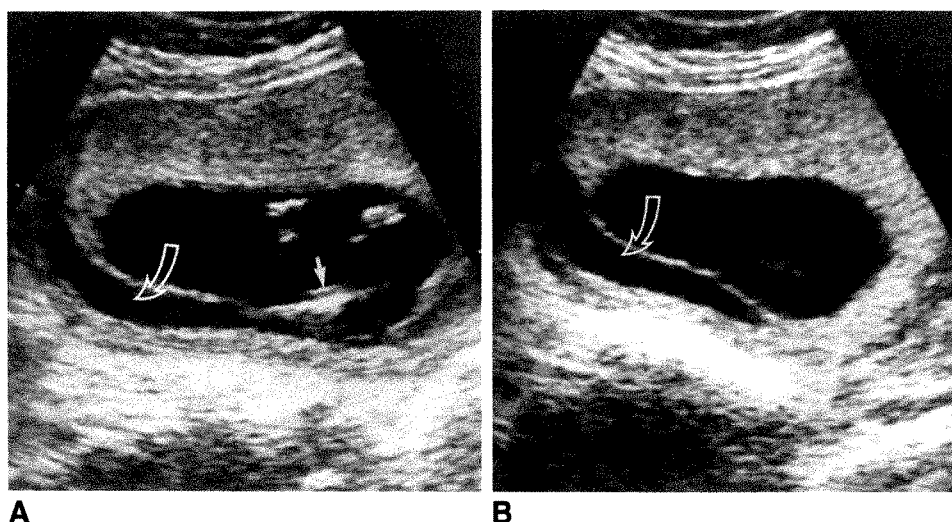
A and B, Transverse (A) and longitudinal (B) sonograms at 14 menstrual weeks show subchorionic hemorrhage (open arrows) (estimated volume, 50 ml) elevating membranes and border of placenta. Note short segment of amniotic membrane (solid arrow). Pregnancy was successful.
